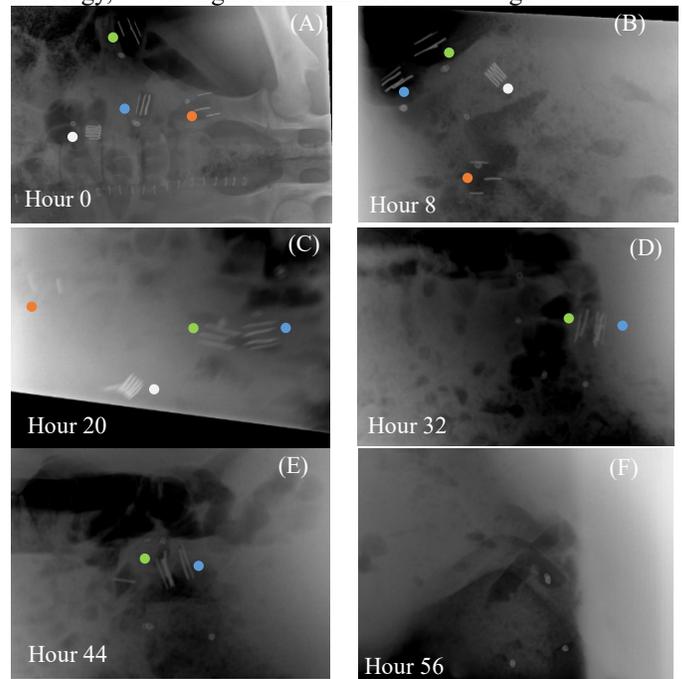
X-ray of the migration vs. thickness experiment. White, orange, blue, and green dots indicate the control capsule, the rigid stent, the thicker soft stent, and the thin soft stent. The control capsule and the rigid stent both moved further away from their markers 20 hrs. after the surgery.
